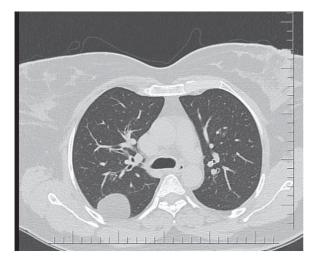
Non contrast enhanced CT chest – lung window – representative image
